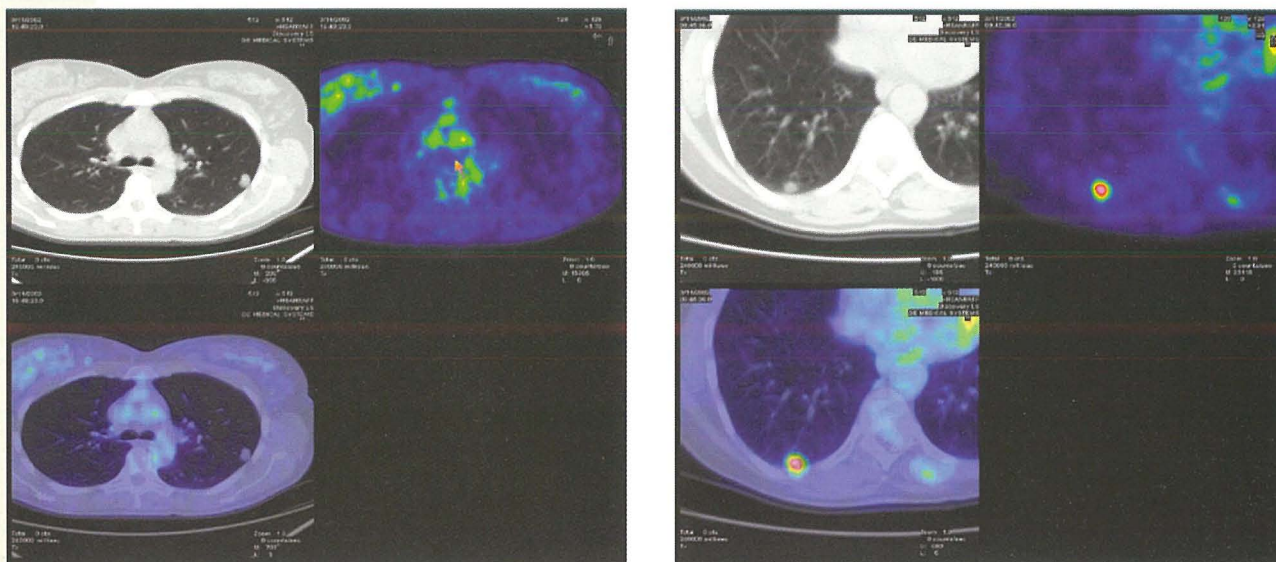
Two patients presenting with a pulmonary nodule. In one patient (above left), the nodule showed no tracer uptake, and a biopsy was avoided. In the other patient (above right), the nodule showed avid tracer uptake. Moreover, whole-body PET/CT allowed immediate staging of the patient with the very suspicious lung lesion. Metabolic characterisation of pulmonary nodules is also very important when these are located in areas which are impossible to reach by a biopsy needle (Images courtesy of HSR, Milan)
